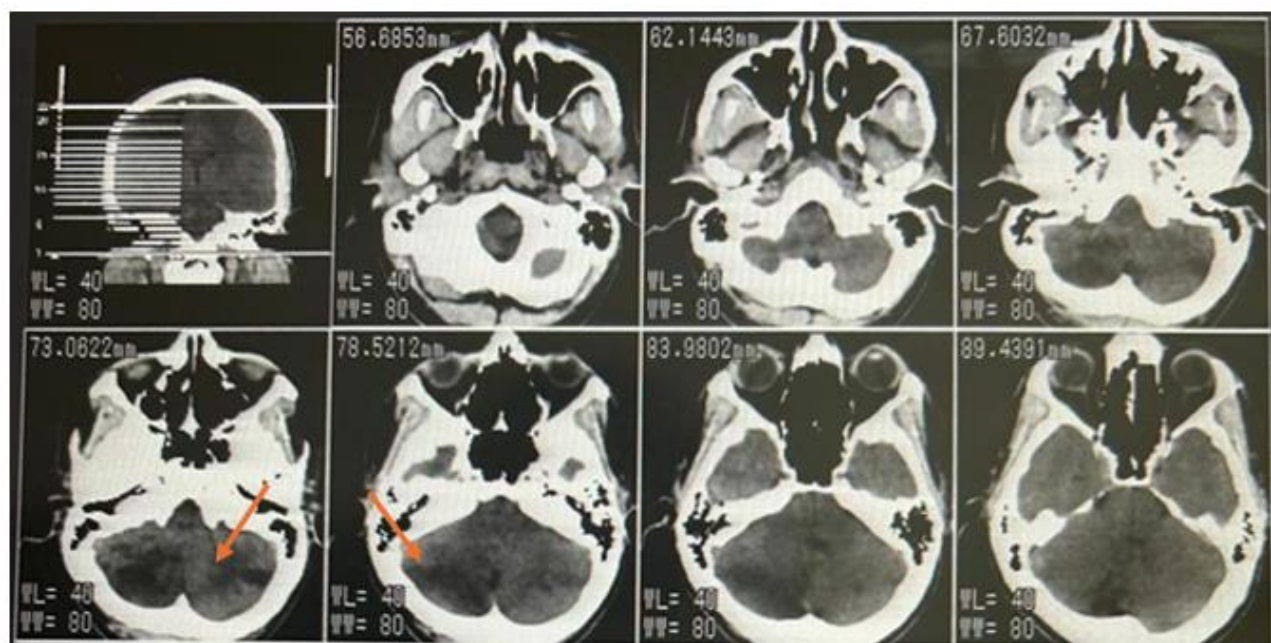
Non-contrast Computed Tomography brain on day 2 of admission showing bilateral cerebellar infarctions (arrows)
